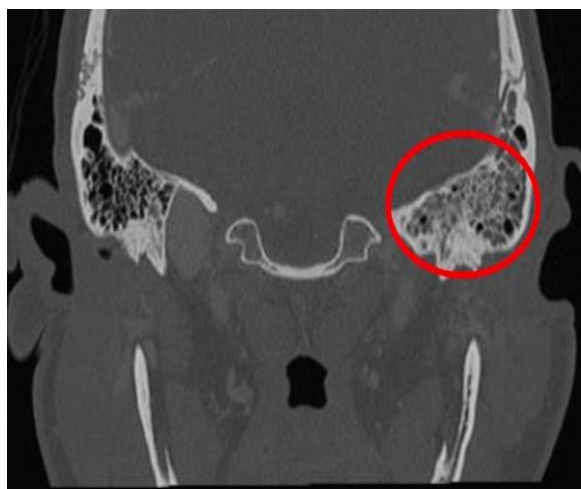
Left sided otomastoiditis on HRCT Temporal Bone
